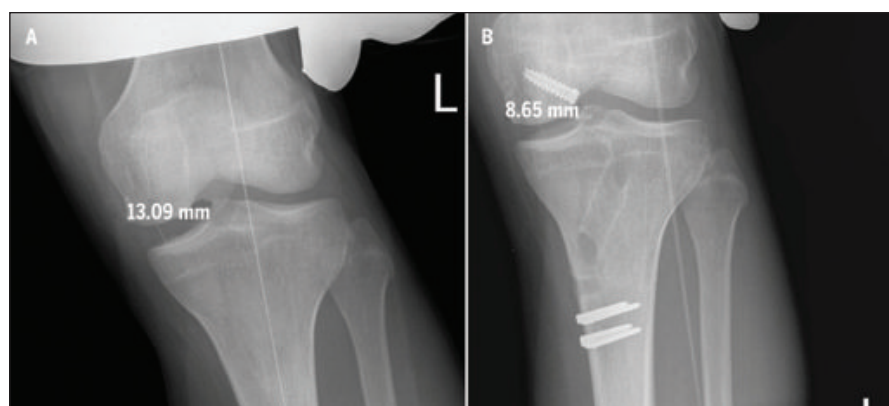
Preoperative (A) and postoperative (B) valgus stress radiographs (left knee).
